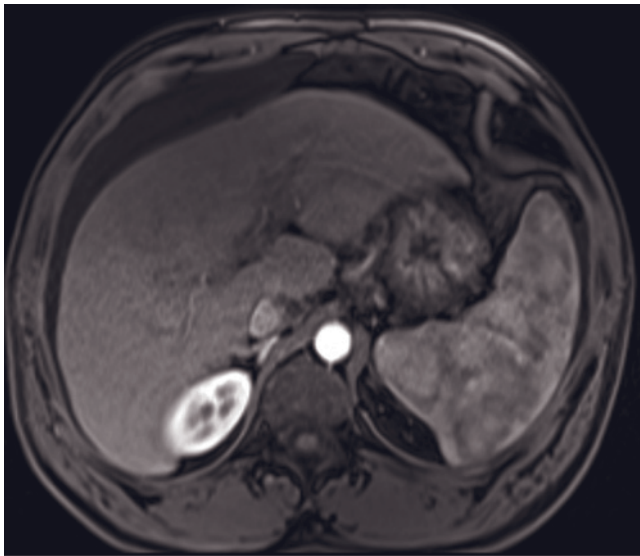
(Continued) T1-weighted GE (*b*), T1-weighted fat-suppressed GE (*i*), HASTE (*j*), immediate postgadolinium T1 GE (*k*), and 90-s postgadolinium T1 fat-suppressed GE (*l*) images. Relative to normal liver, normal adrenal glands are typically mildly hypointense on T1 in-phase images (*b*, *b*), are isointense with a signal-void rim on T1 out-of-phase images (*c*), are well defined and isointense on T1-weighted fat-suppressed images (*d*, *i*), are isointense on T2 images (*a*, *e*, *j*), enhance homogeneously on immediate postgadolinium images (*f*, *k*), and fade to isointensity with liver on delayed images (*g*, *l*). T1-weighted SGE (*m*), T1-weighted
